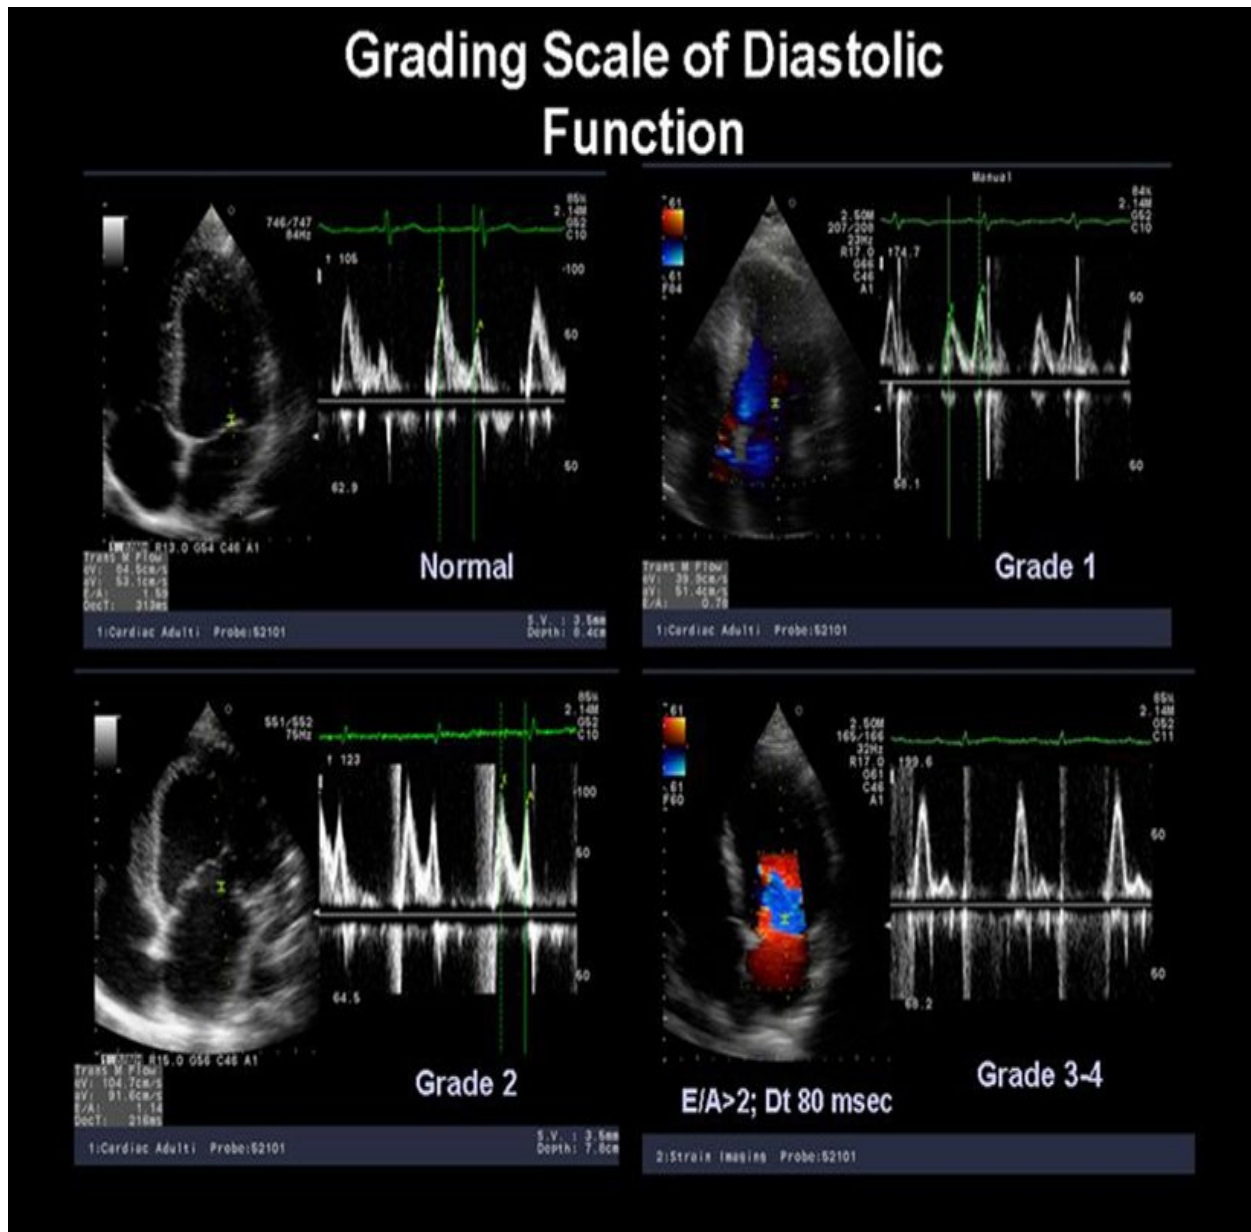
Grading of diastolic dysfunction from normal to severe dysfunction (grade 3-4), evaluated by Pulse Wave (PW) Doppler of mitral inflow. Normal: DT 140-240 msec; E/A 0.75-1.5. Grade 1: DT > 240 msec, E/A < 0.75. Grade 2: DT 140-240 msec, E/A 0.75-1.5. Grade 3-4: DT < 140 msec, E/A > 1.5; in grade 3, the E/A ratio is reversible, when compared to grade 4, with the pre-load changes.
